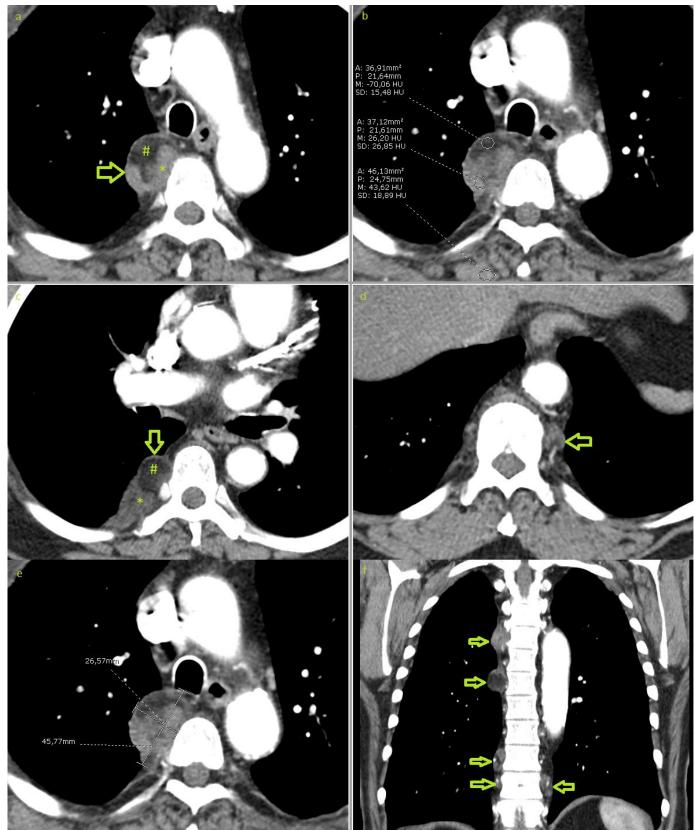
70-year-old male with bilateral multifocal extra-adrenal myelolipoma. Contrast enhanced CT of the chest in an arterial phase demonstrating a well-circumscribed right paravertebral mass at the level of the aortic arch measuring 45x26x56mm(a & e). The mass shows mixed density, partially hypodense with -70 hounsfield units (b) due to fat content (#) and partially hyperdense due to myeloid tissue (*). Multiple smaller lesions are shown bilaterally (arrows in c, d & f). No infiltration of the neighbouring tissues. (Technique: 16-MDCT scanner, Automatic tube current modulation ranging between 131 and 250 mA, 120KVp. 5mm slice thickness. Soft tissue window, level/width: 15/350. i.v. injection of 60ml of 300mg/ml iodine concentration non-ionic contrast. a)- e) axial plane, (f) coronal reformation).
